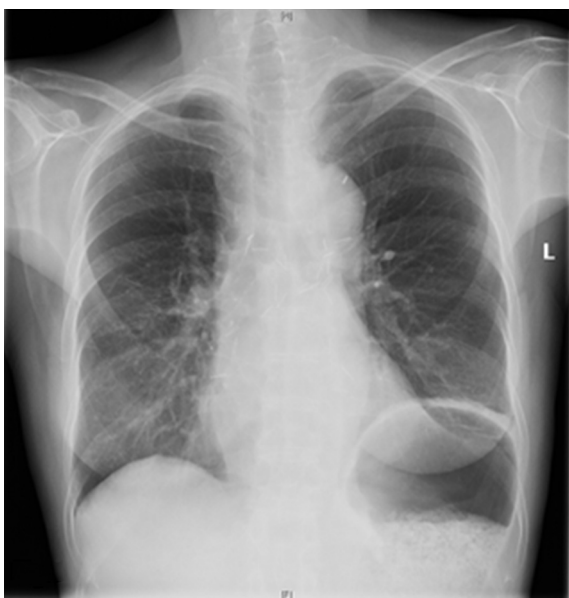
Pulmonary nocardiosis in a 59 year-old-female double-lung transplant recipient two years after transplantation. Nine months later chest x-ray was nearly normal and infiltrations were closely gone – still on oral treatment with TMP-SMZ.
